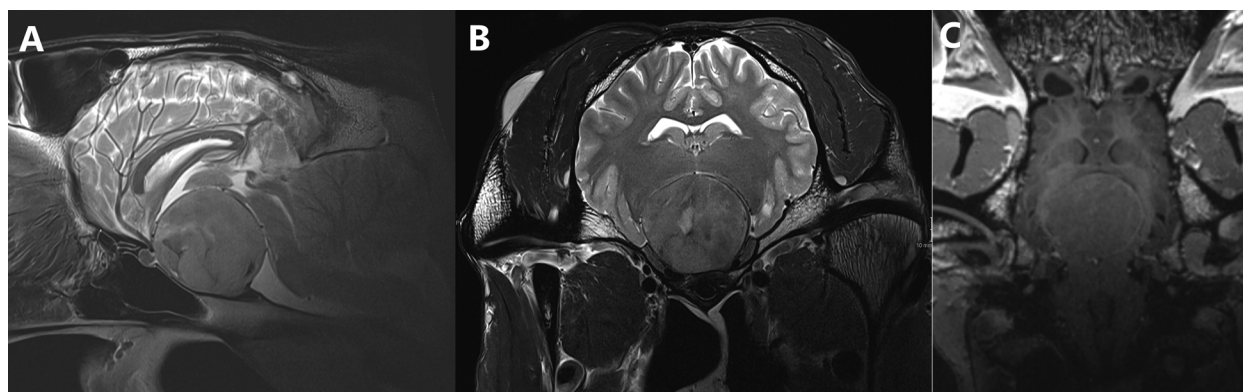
(A) T2w sagittal, (B) T2w transverse and (C) T1w 3D reconstructable magnetization-prepared gradient-echo (MP-RAGE) with contrast medium (gadoteric acid, clariscan™, GE Healthcare AG, opfikon, Switzerland) dorsal magnetic resonance images of the head of a 16-year-old warmblood mare, depicting a large well-delineated pituitary macroadenoma compressing the thalamus, the midbrain, and the optic chiasm.
